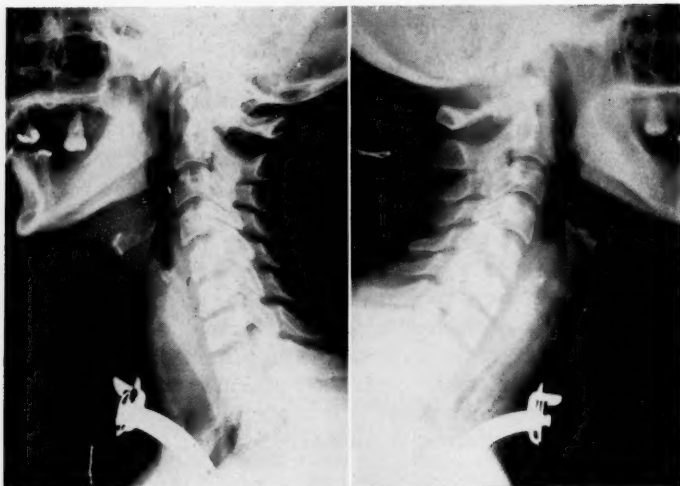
Preoperative lateral roentgenogram of neck, showing complete stenosis.
